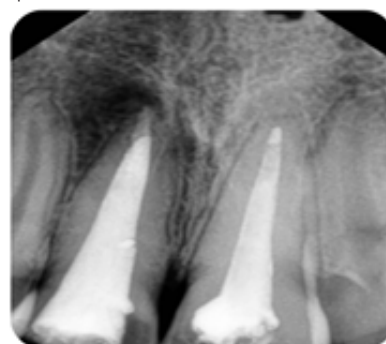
14 Months follow up Radiograph
